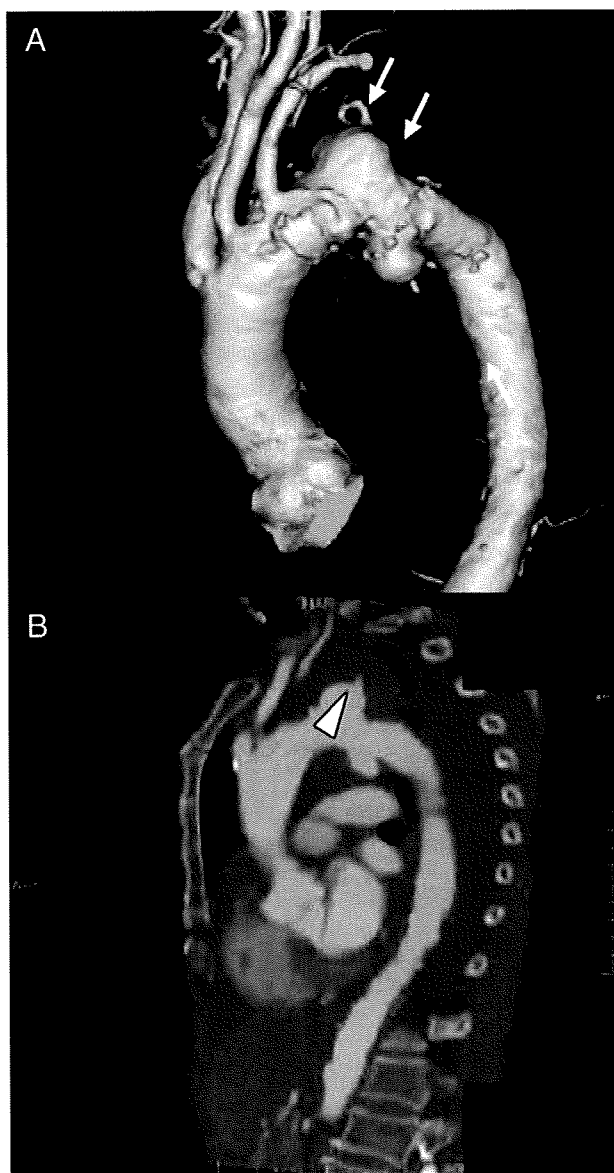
(A) A 64-slice computed tomography (CT) showed massive aortic aneurysm (arrows), and (B) wall thickening in aortic arch (arrowhead).
